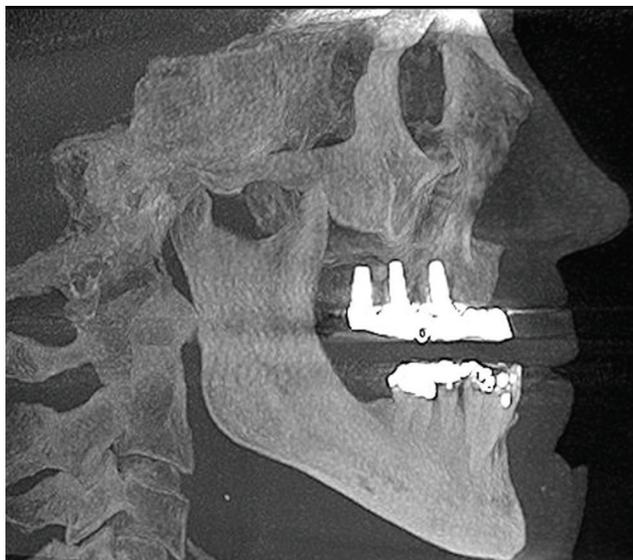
Radiograph showing the bar with a passive fit and labial position relative to the crest of the ridge.
